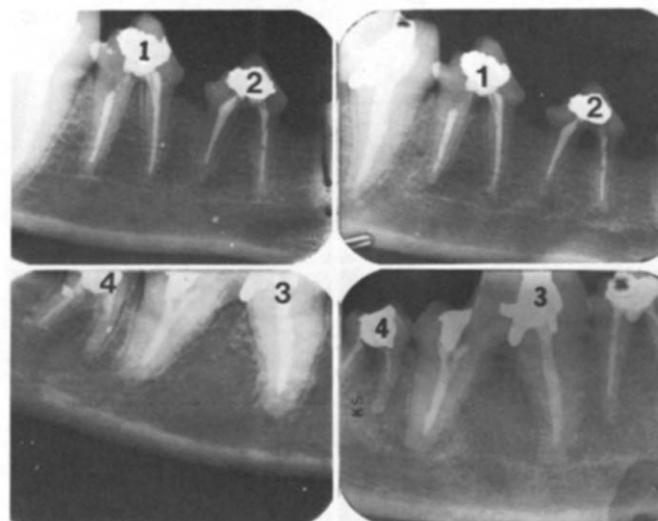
Left, top and bottom, immediate postoperative radiographs of tooth 1: perforation filled with calcium hydroxide; tooth 2: perforation filled with Cavit; tooth 3: perforation filled with amalgam; tooth 4: control. Right, top and bottom, three months postoperative radiographs.
